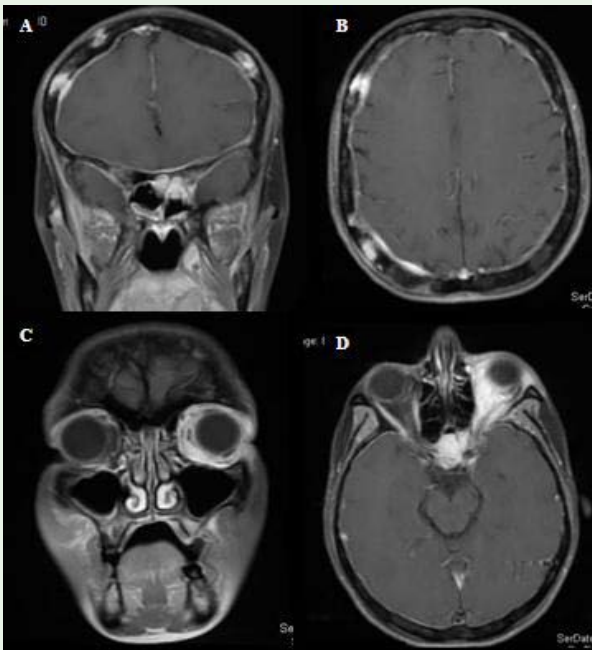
(A +B) Brain Magnetic Resonance Imaging (MRI) revealed abnormal meningeal enhancement. (C+D) MRI showed a meningeal nodular infiltration with extension to left orbital associated to exophthalmia grade 1.
